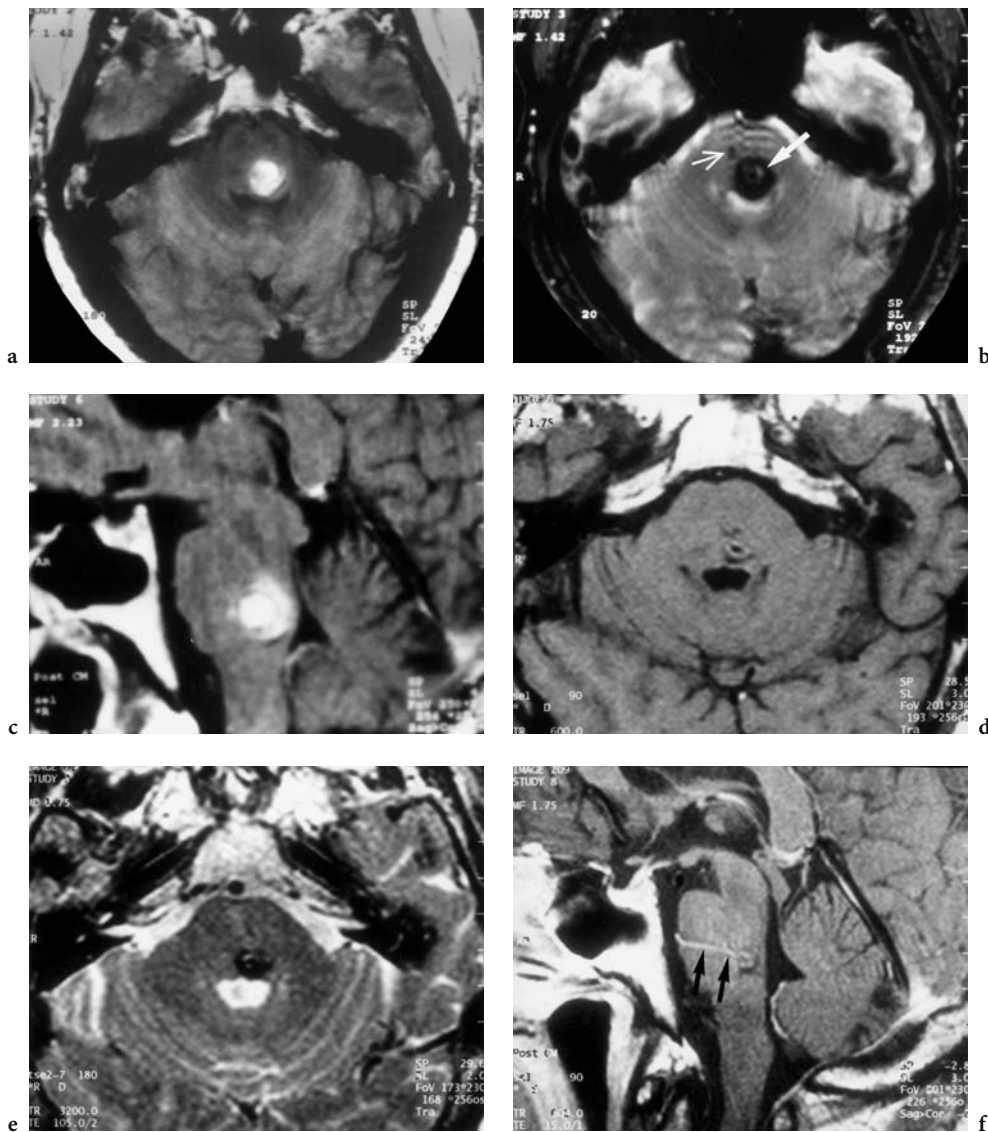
Follow-up of a 63-year-old man with sudden onset of left NV and NVI paresis. Diagnosis: acute brainstem cavernoma hemorrhage with associated DVA (developmental venous anomaly). MRI initial examination: a Axial T1-weighted native image showing left paramedian predominantly hyperintense lesion in the rhombencephalon corresponding to the presence of acute to subacute hemorrhage. b Corresponding T2-weighted image with hypointense hemorrhage signal but intermediate part (*big white arrow*). The *small white arrow* indicates the draining vein of the DVA. c Left paramedian sagittal view demonstrating slight space-occupation by the hemorrhage with expansion to the floor of the fourth ventricle. Corresponding images of a second MRI done 3 months later: d Axial T1-weighted native image enabling detection of recurrence of the hemorrhage by a small target-like formation in the parenchyma of the brainstem. Note enlargement of the fourth ventricle diameter (compare with a). e Axial T2-weighted view with characteristic hypointense hemosiderin deposit (compare with b). f Midsagittal T1-weighted, contrast-enhanced view, demonstrating the perfating draining vein of the DVA, clearly visualized after i.v. gadolinium. [With permission of Radiologen am Brand, Mainz (a–c), Dr. Müller-Forell, Institute of Neuroradiology Medical School, Mainz]
